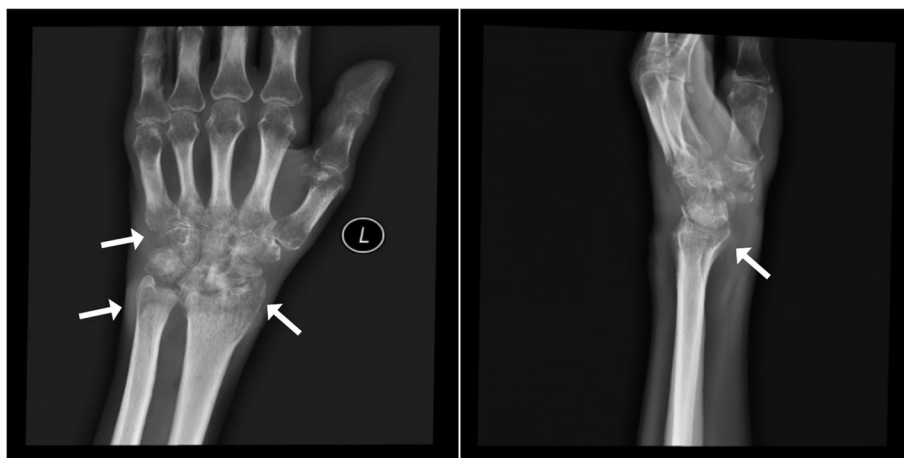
Anteroposterior and lateral wrist radiographs revealed erosions of the distal radius, distal ulna and carpal bones. (White arrows)
